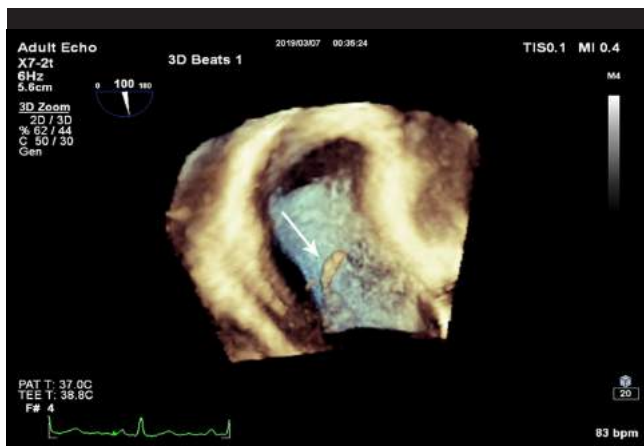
Three-dimensional transesophageal echocardiography, showing the clot attached to the interatrial septum (arrow)
